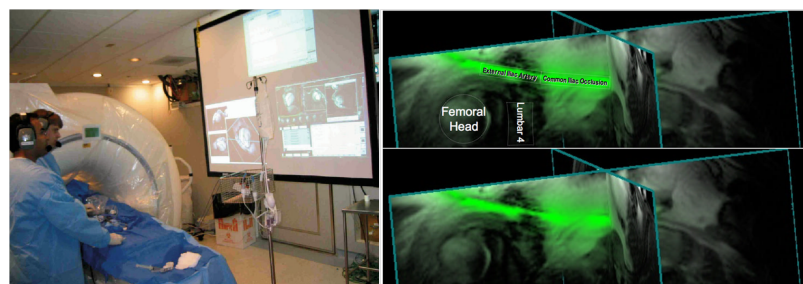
Example of intraoperative MRI angiography: setup and exemplary image showing 2 MRI slices rendered and a vessel highlighted in green. Pictures taken from [82] and reproduced with permission of Elsevier.
